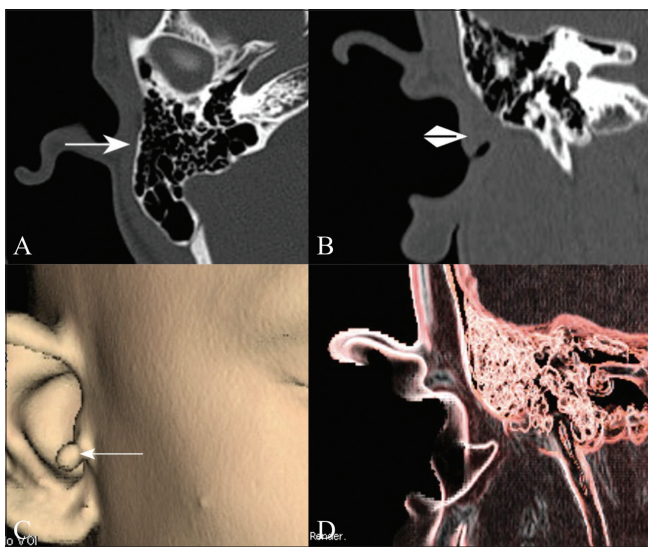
(A-D): EAC atresia. Axial HRCT image (A) shows a well-pneumatized atretic plate (arrow). Coronal HRCT image (B) shows atresia of the bony (arrow) and cartilaginous (arrowhead) parts. 3D surface-rendered image (C) shows an accessory tragus in the right ear. 3D volume rendered image of the right EAC (D) shows atresia
